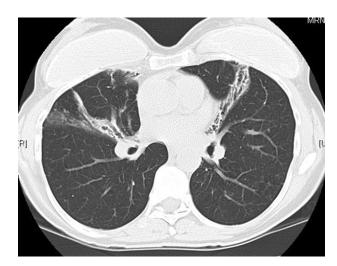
This computed tomography scan demonstrates focal bronchiectasis of the right middle lobe and lingula characteristic of elderly women who present with nontuberculous Mycobacteria infection. (L = left; R = right.)
